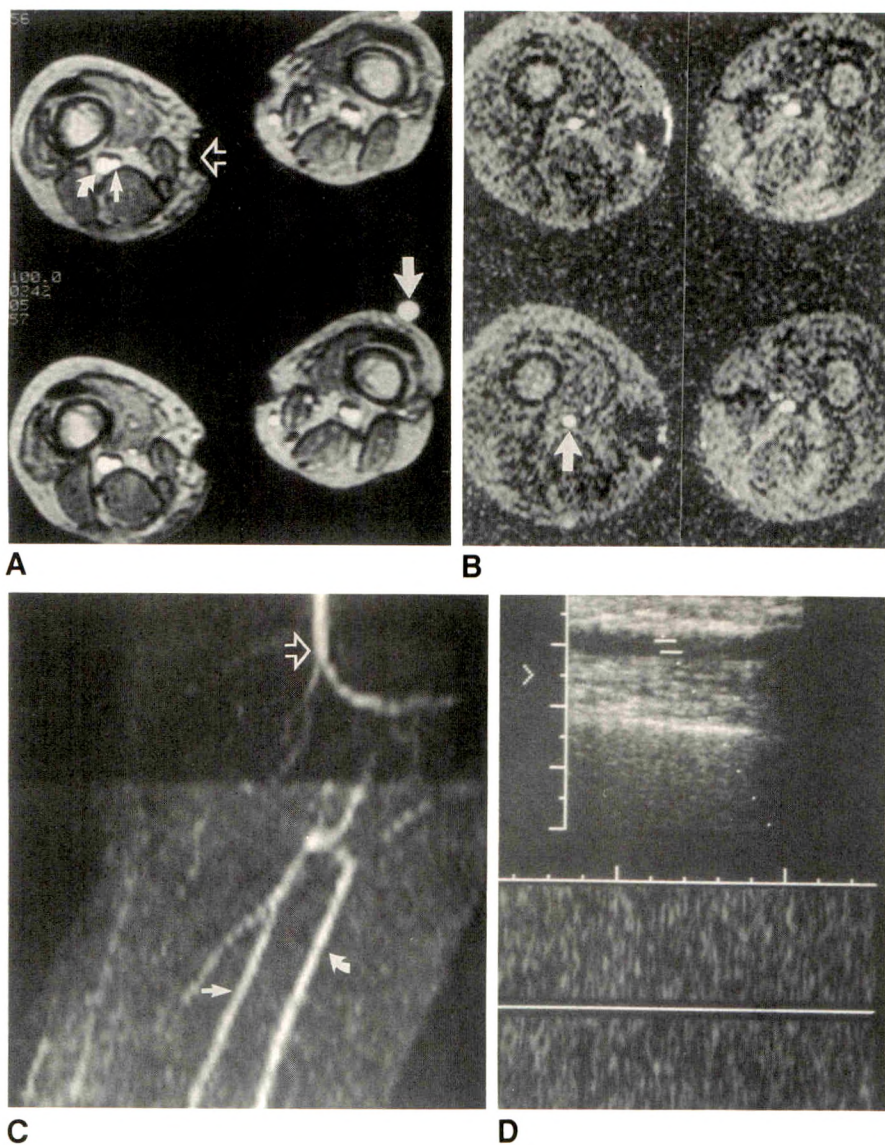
A, Axial gradient-echo (36/13/30°) MR images through distal thigh with saturation band below imaged volume. Femoral vein (curved arrow) is not adequately suppressed. Small straight solid arrow = superficial femoral artery; open arrow = clip artifact from saphenous vein harvesting; large straight solid arrow = gadolinium marker.
